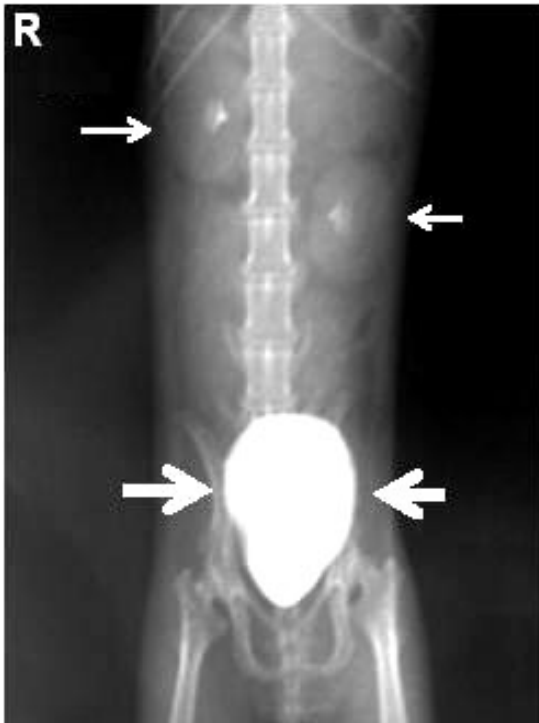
Lateral view radiograph of pyelogram and cystogram phases. Small arrow: pyelogram phase and large arrow: distended urinary bladder.
